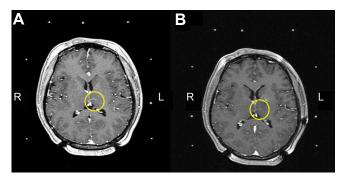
T1-weighted double-dose gadolinium-enhanced brain MRI scans of a 34-year-old female patient treated with levodopa for 10 years, presenting with aggravated peak dose dyskinesia.
